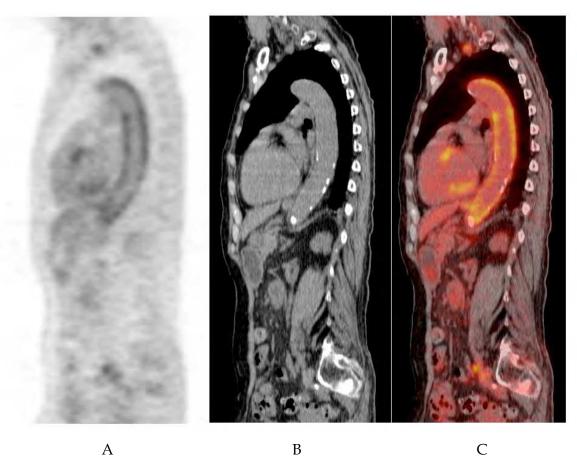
Sagittal view of inflammation of the descending thoracic aorta (A : PET, B: CT-scan, C: fusion of the PET and CT-scan images).
